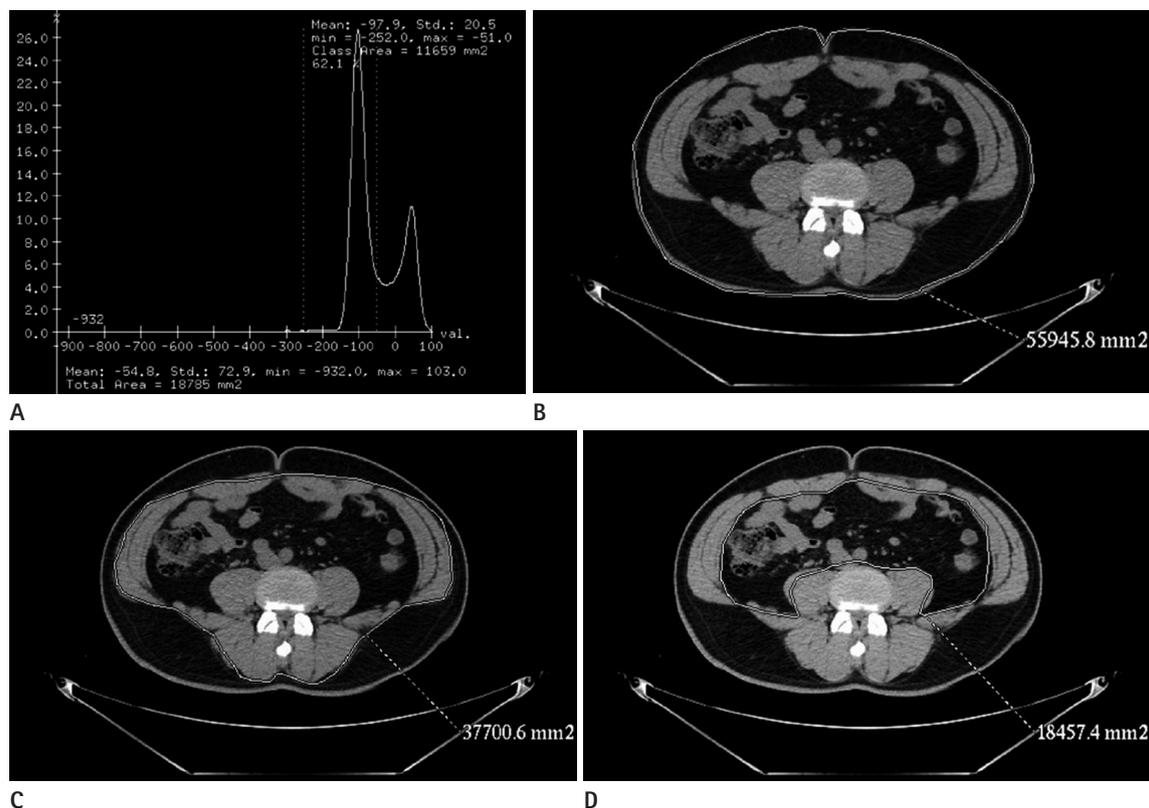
Measurement of visceral and subcutaneous fat using a 64-slice multidetector CT with AW version 4.5.
